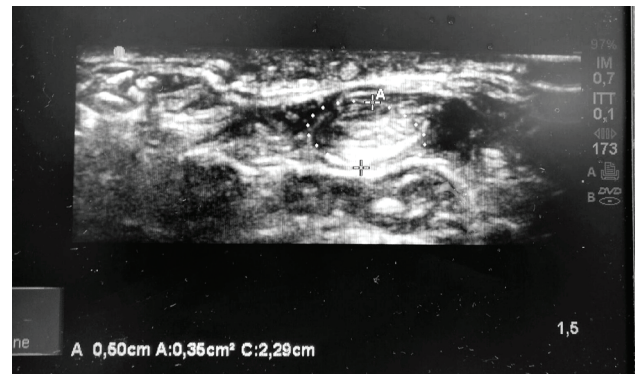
Ultrasound study. Patient affected by carpal tunnel syndrome.
